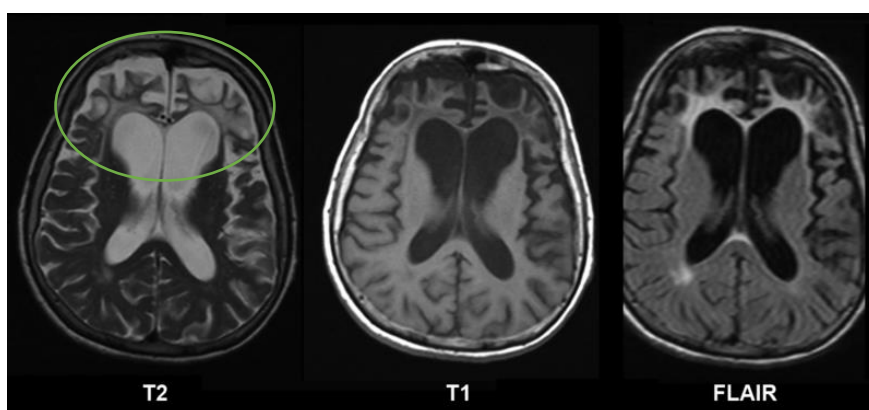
Bifrontal lobe atrophy seen on MRI. Modified from "Viquipèdia - Pick's disease" (free-license image) (23).
